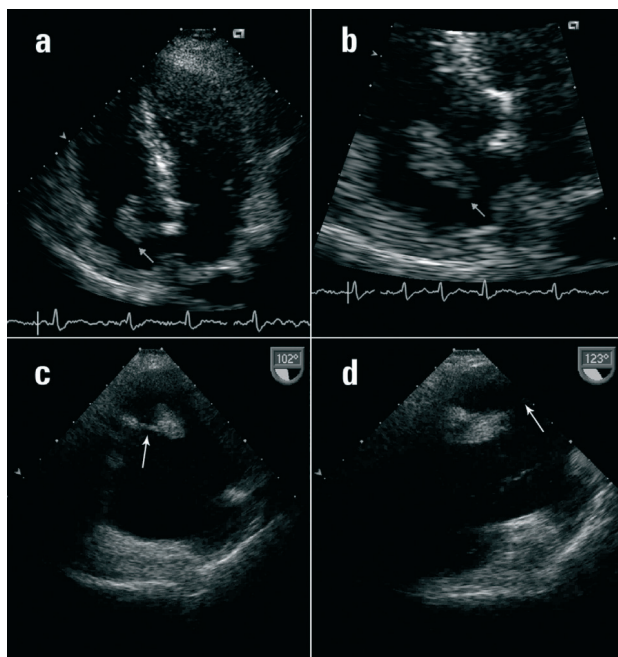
Transthoracic echocardiography. a. Apical plane showing an ovoid mass inside the right atrium. b. Apical plane with enhanced image of the right atrium, showing how the intracavitary mass is connected to the atrial septum. c & d. Transesophageal echocardiography showing the lobulated mass inside the right atrium, formed on Chiari's network (arrows).
